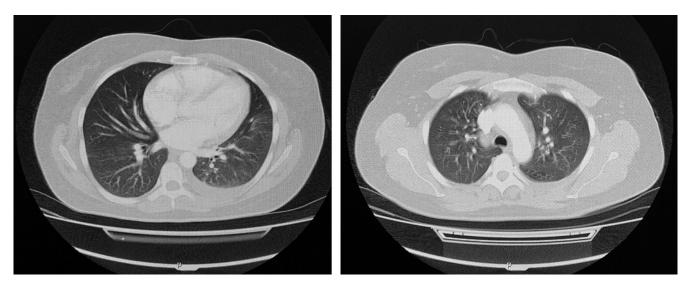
Chest CT angiography: thrombus at the level of the right lower lobar segmental branch, right pleural effusion, and atelectasis. Images property of the authors.
